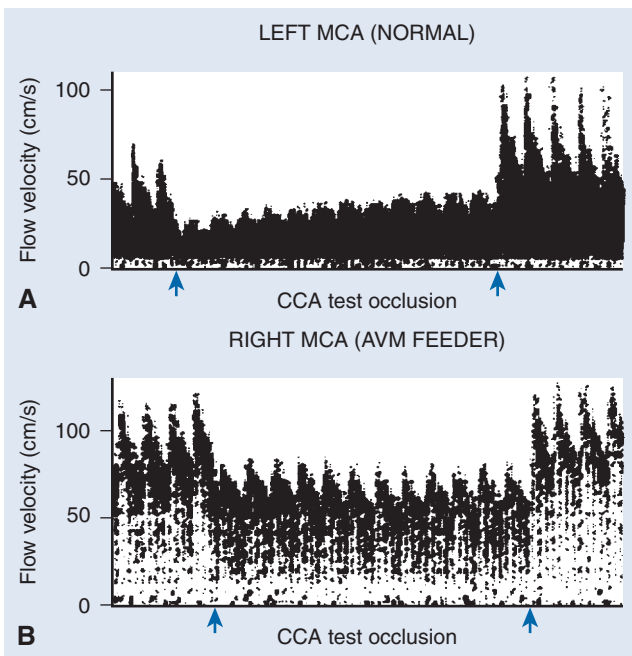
Transcranial Doppler ultrasonography studies in a patient with an arteriovenous malformation (AVM). A, Carotid compression of the ipsilateral normal carotid artery yields a drop in the left middle cerebral artery (MCA) velocity. Gradually, over the course of the compression, flow is recruited from collateral pathways. With release of compression, there is a brief period of hyperemia. B, The right MCA also feeds a large AVM. The low-resistance fistula of the AVM results in much higher flow velocities through the MCA stem. Ratio of systolic to diastolic velocities is different, with the diastolic velocity being much higher in relation to systolic velocity, indicating decreased pulsatility. There is no apparent autoregulatory recruitment of collateral flow and no reperfusion increase in flow velocity, in comparison with the ipsilateral, normal side. (From Aaslid R: *Transcranial Doppler Sonography*. New York, Springer-Verlag, 1986.)
